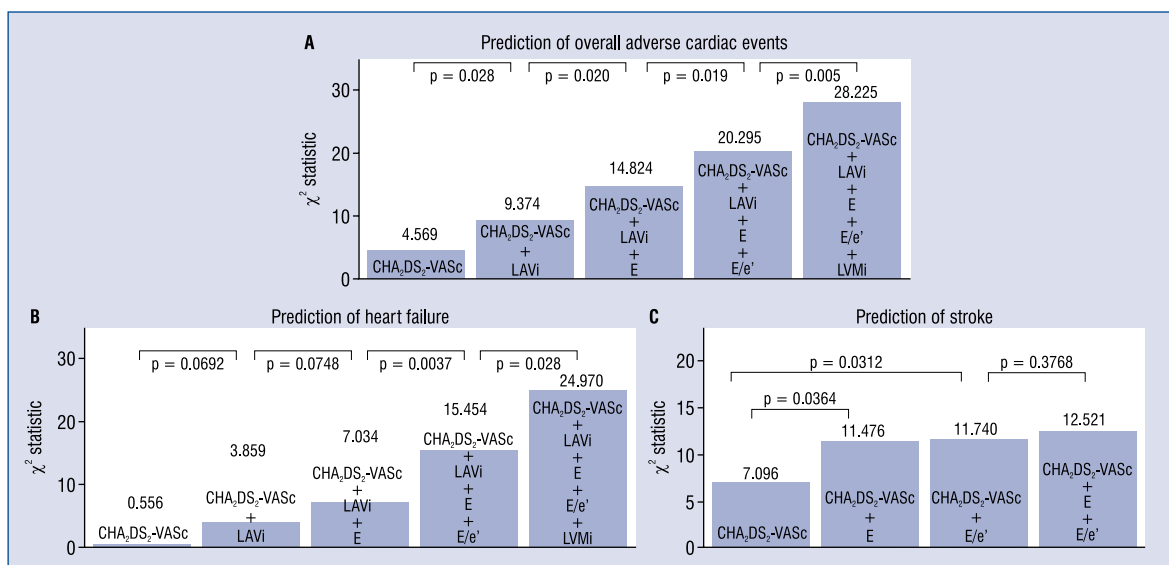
Incremental value of echocardiographic parameters for predicting future cardiovascular events. Nested regression models for predicting overall adverse cardiac events (A), heart failure (B), and ischemic stroke (C). The first step consisted of CHA₂DS₂-VASc score. Then left atrial volume index (LAVi), peak mitral early filling velocity (E), peak early filling velocity to tissue Doppler mitral annular early diastolic velocity ratio (E/e') and left ventricular volume index (LVMI) were successively included in the next steps.
